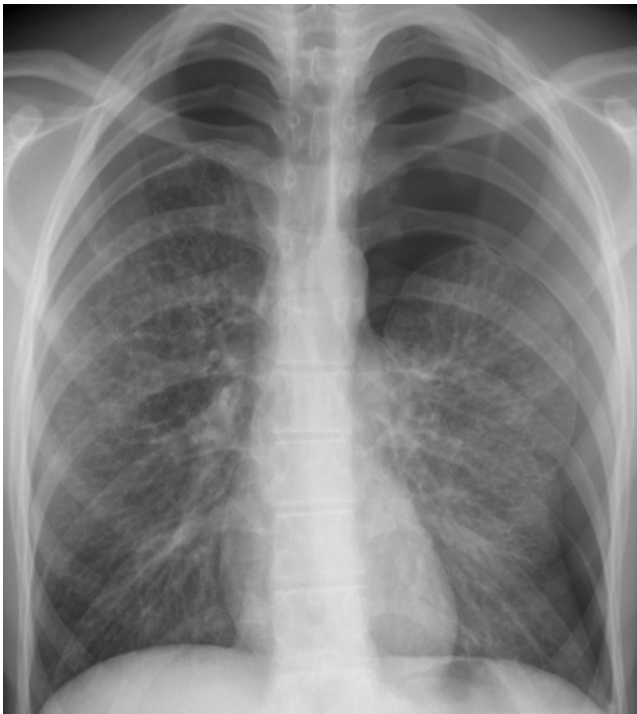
Chest radiograph with bilateral pneumothorax.
